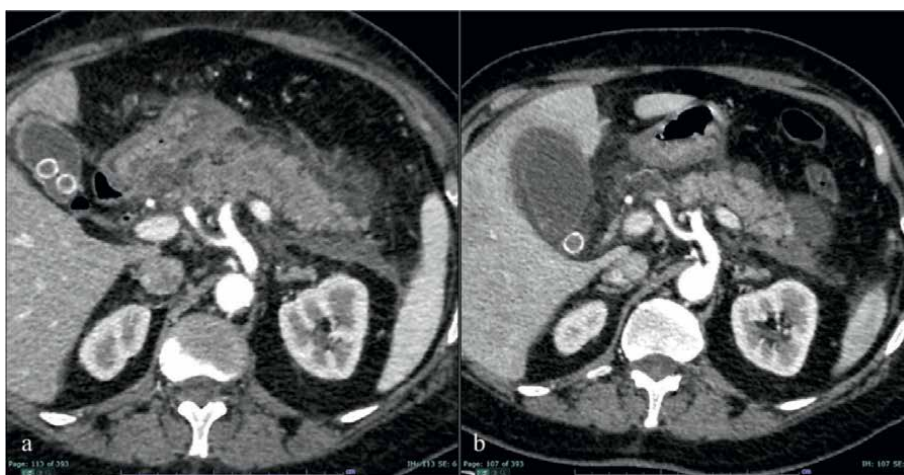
F, 64 yo, affected by an acute interstitial edematous pancreatitis; At CT a homogeneous decreased enhancement of the entire pancreas is appreciable with no evidence of non-enhancing areas (a); at the level of the tail, a peripancreatic collection is noticeable (b).
